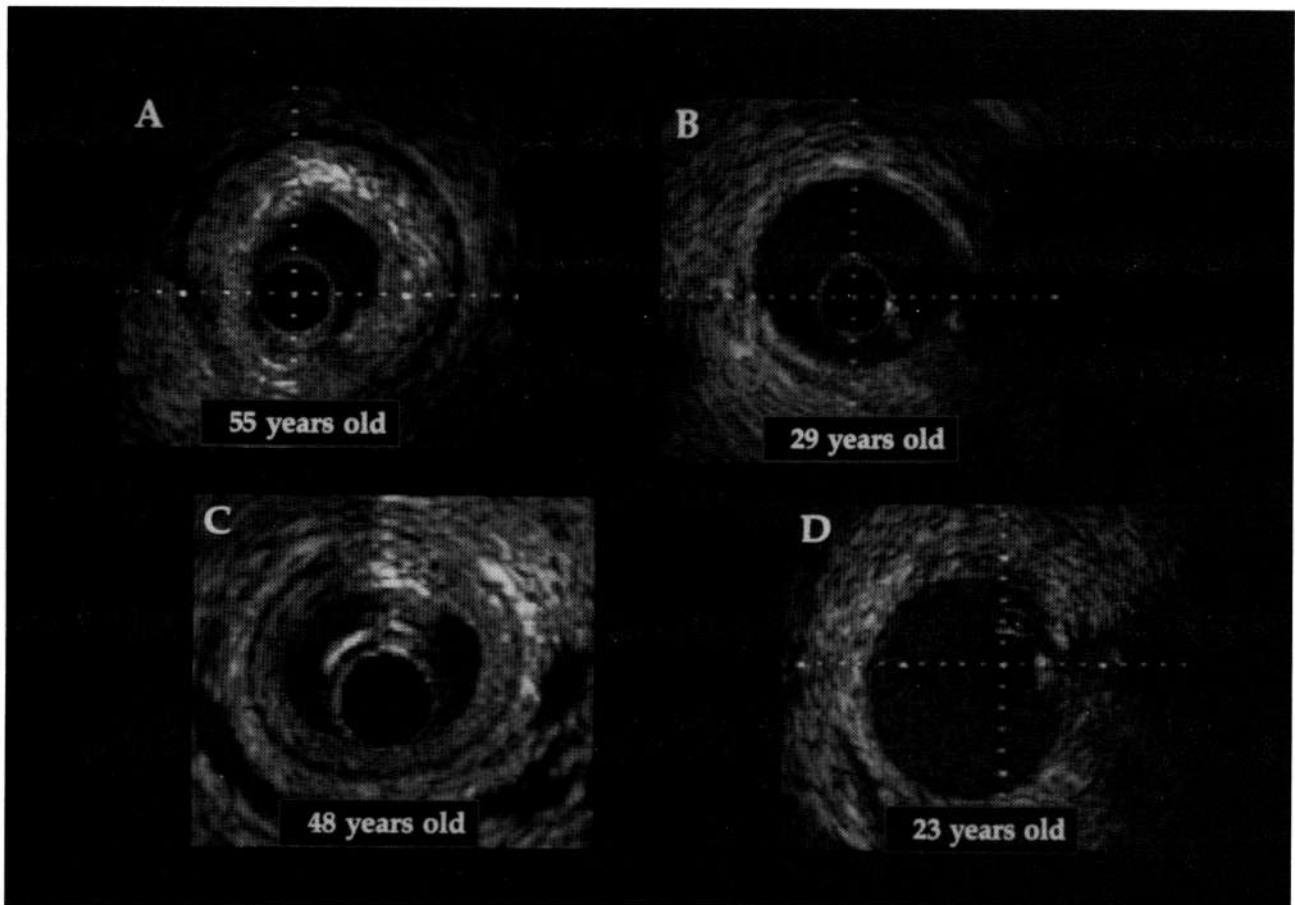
Representative *in vitro* and *in vivo* coronary ultrasound images from patients of different ages. Clear layering on the ultrasound images is seen in the older group (panels A and C), but little evidence of layering is apparent in the younger hearts (panels B and D).
